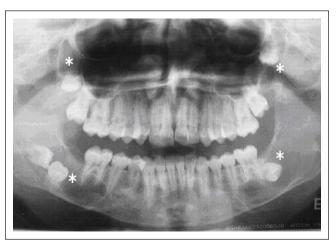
Radiograph shows keratocysts in mandible and maxilla (asterisks)
